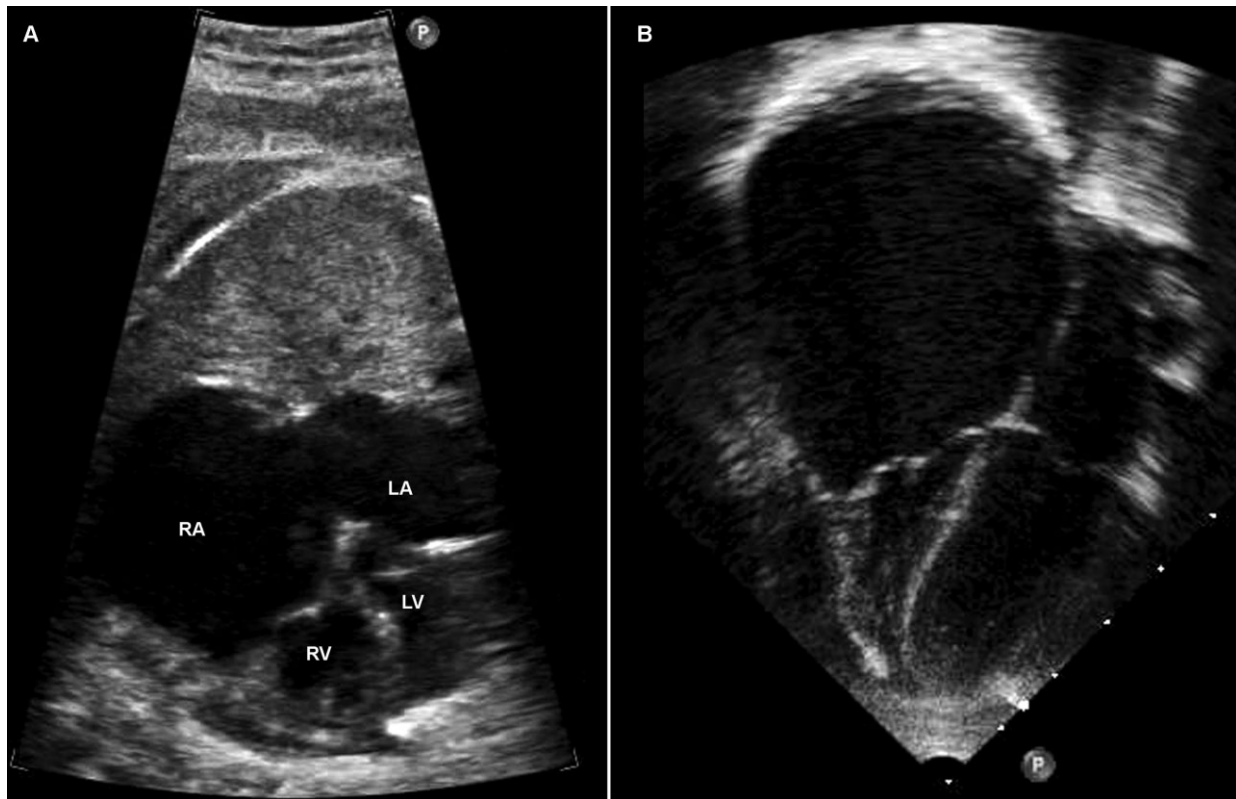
Case 5. (A) Fetal echocardiogram, 36 weeks gestation. A four-chamber view demonstrating a giant right atrial aneurysm contiguous with the main body of the right atrium. (B) Postnatal echocardiogram. RA, right atrium; LA, left atrium; RV, right ventricle; LV, left ventricle.
